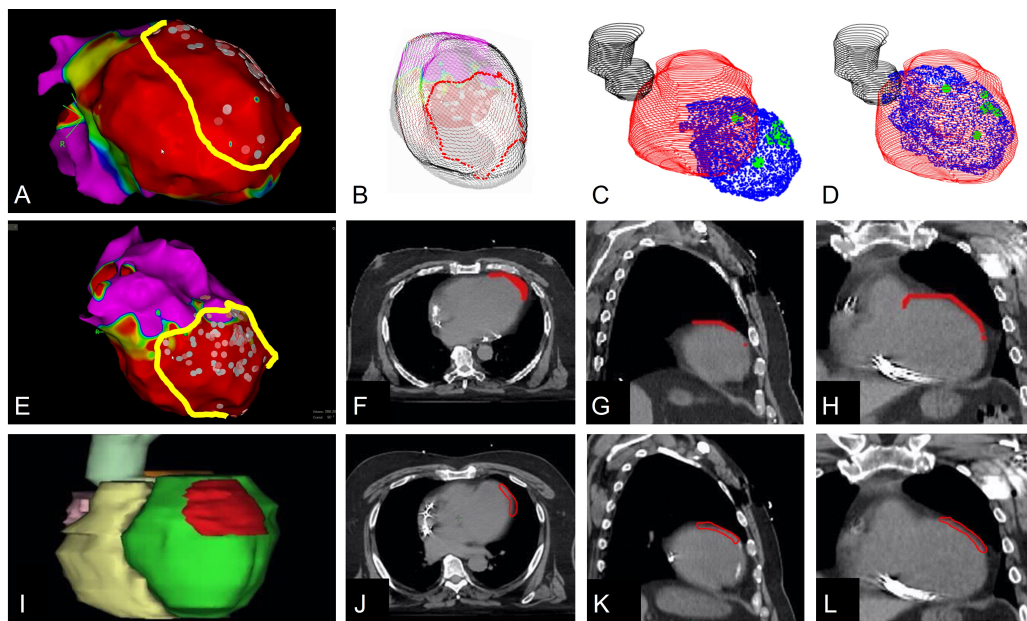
Case 5. (A, E) Electroanatomical mapping (EAM) data with the marked ventricular tachycardia (VT) target region (yellow) in superior and anterior-posterior views from CARTO 3 system. (B) 3D view of the left ventricle (LV) point cloud and the 2D-3D registered VT target points (red). (C) Computed tomography (CT) contours (red: LV; black: aorta) and EAM data (blue: LV; green: ablation points) before the 3D-3D registration. (D) CT contours and EAM data after the 3D-3D registration. (F-H) Axial, sagittal and coronal CT slices with marked (red) region by 2D-3D match; (I) 3D structures from the planning CT with final clinical target volume (CTV, red), LV (green), right ventricle (yellow) and aorta (light green). (J-L) Axial, sagittal and coronal CT slices with the final treated CTV (red, without assistance of the CARDIO-RT software).
